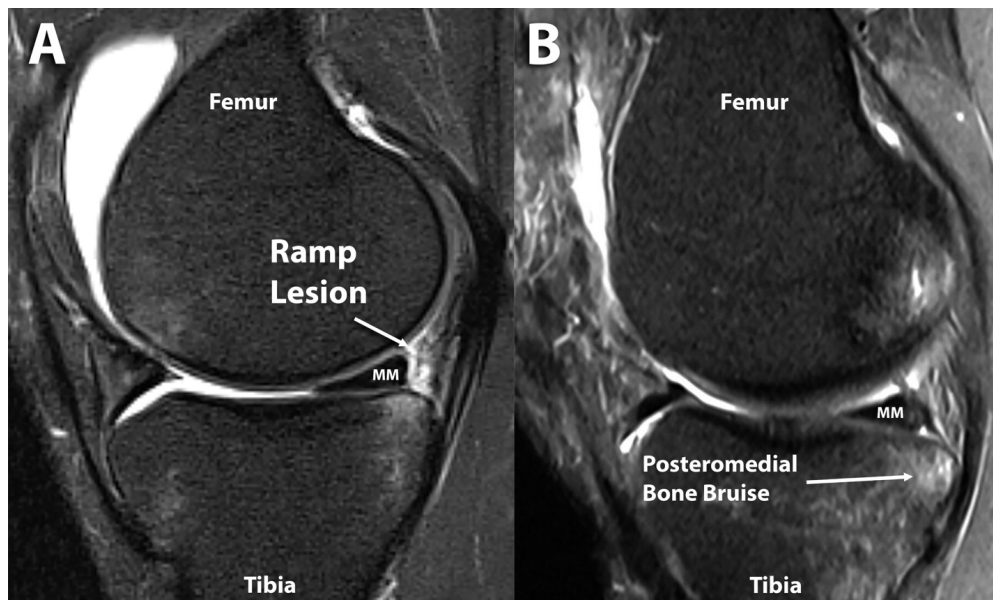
Preoperative MRI demonstrating meniscal ramp lesion and associated posteromedial tibial bone bruise pattern, best visualized on sagittal fat-saturated T2-weighted images. (A)
